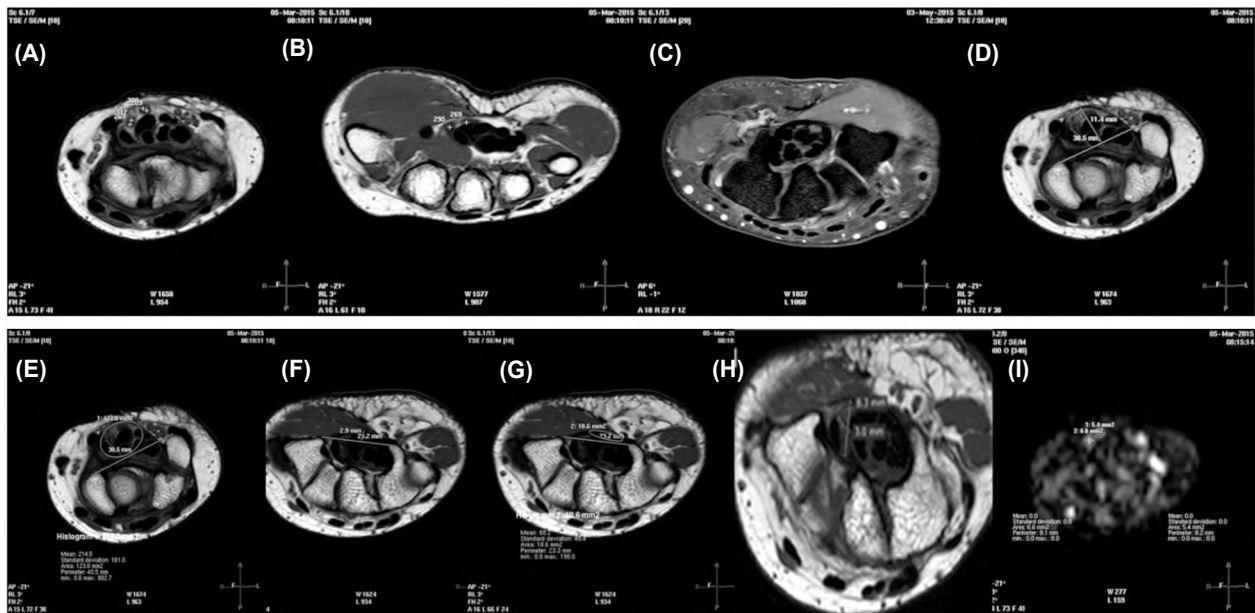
A 43-year-old female patient with history of left hand parasthesia and pain along MN distribution. She had positive Phalen, Tinel and Durkan's tests. On EPS results, she had mild entrapment on MN. (A,B,C) Axial T2 WI & PD with fat suppression WIs show bifid MN along its whole pathway throughout CT from its inlet to its exit; the MN was markedly hyperintense compared to the thenar muscle (D,E) Axial T1 WIs at the level of CT inlet shows FR bowing height was 11.4 mm and bowing area of 123 mm<sup>2</sup> (F,G) Axial T1 WIs at the level of CT outlet shows FR bowing height was 2.9 mm and bowing area of 18.6 mm<sup>2</sup> (H) Axial T1 WI shows MN flattening ratio at the level of hook of hamate was 2.7 (I) Axial DWI at the level of pisiform bone show bifid MN with CSA of the top one was 5.4 mm<sup>2</sup> and the caudal one was 6.6 mm<sup>2</sup>.
